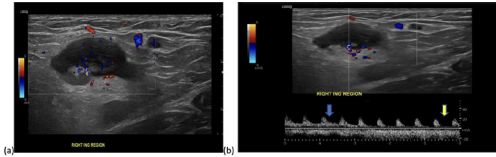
This 31-year-old patient who was referred to ultrasound because of right inguinal pain and swelling revealed an enlarged inguinal lymph node with preserved fatty hilum (a). Spectral Doppler interrogation of the artery at hilum for educational purposes was done to show the effect of compression on the spectral waveform, in which diastolic component (blue arrow in b) is reduced when heavy hand technique is used (yellow arrow in b) hence the Doppler indices is affected by the change in diastolic component.
